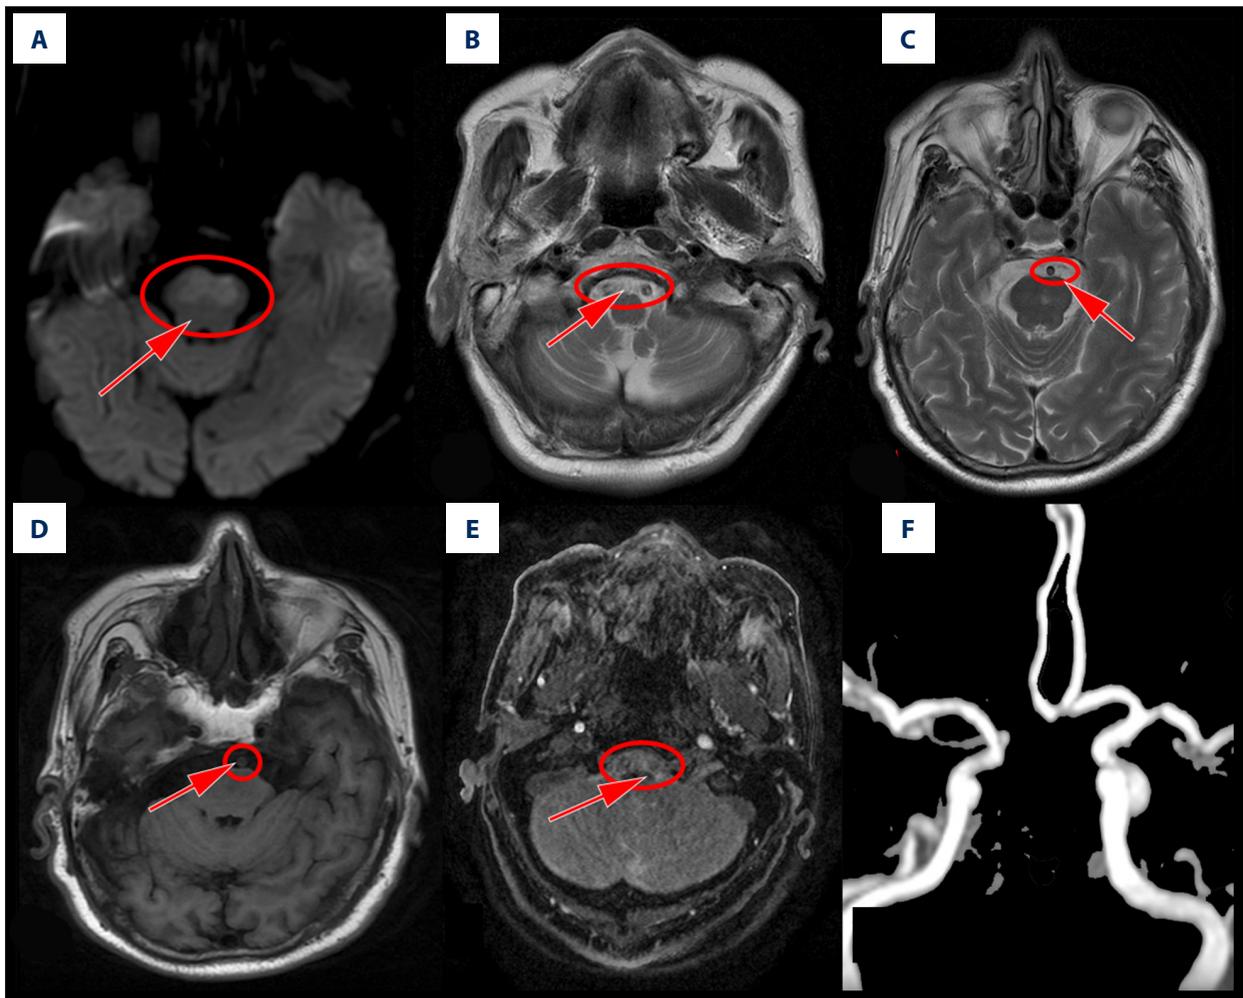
Example of HEVs in a PPCI patient who had the basilar artery occlusion and the corresponding bilateral middle brain cerebral peduncles infarctions. This patient was hospitalized with lack of consciousness. (A) DWI showed that the acute middle brain infarctions (arrow). (B, C) MRI T2 showed that the blood flow void phenomenon of the bilateral vertebral artery and the basilar artery disappeared and HEVs were detected (arrow). (D, E) MRI T1 and 3D-TOF also showed that the basilar artery flow void phenomenon disappeared (arrow). (F) MRA indicated the possibility of bilateral vertebral artery and basilar artery occlusion.
